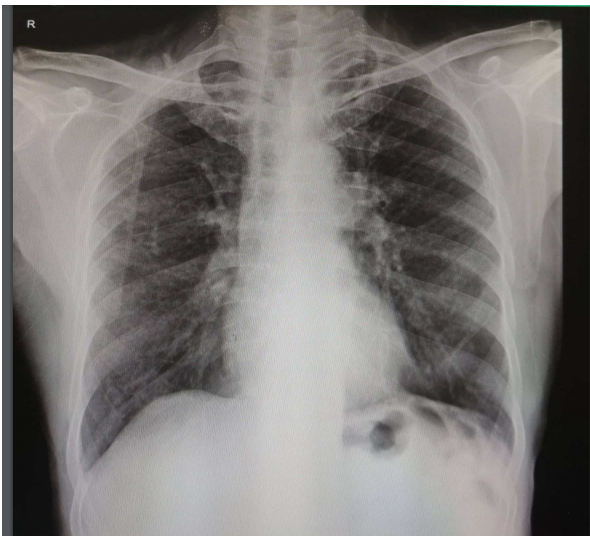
Chest X-Ray Postero-Anterior view shows bilateral hyperinflated lung fields with prominent broncho-vascular markings
